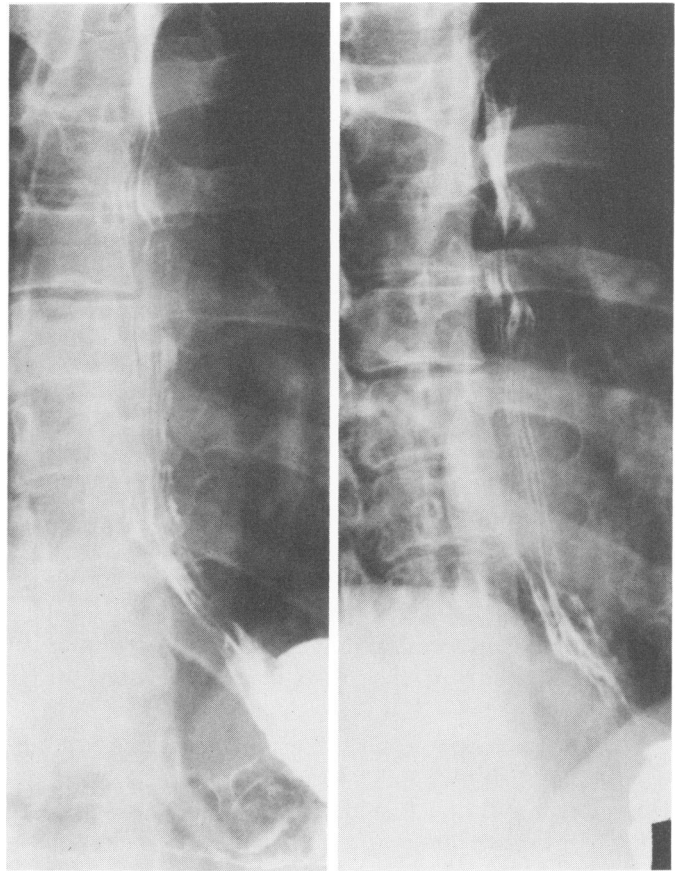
X-ray of the esophagus after therapy.
